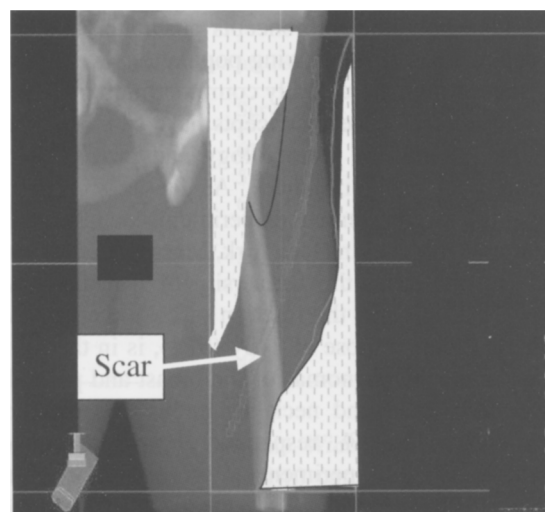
Spindle cell sarcoma of proximal thigh, in a 44-year-old man. Unplanned excision of a 9.5 cm mass. Re-excision with NED, followed by systematic external radiotherapy. Beam's eye view of CT reconstructed conformal irradiation.
